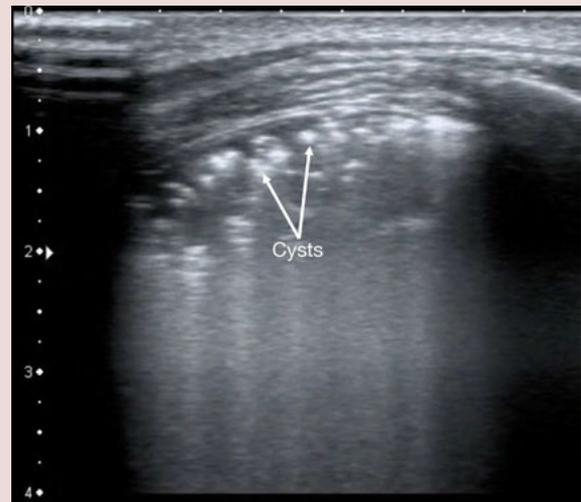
Lung ultrasound changes in a severe case of PCP: Both convex and linear scans show hypoechoic consolidation with irregularly disseminated gas-containing echogenic cysts.
